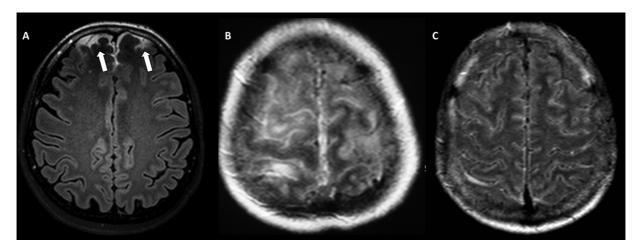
Susceptibility artifact as hyperintense signal within the subarachnoid space. Susceptibility artifact in this case is a hyperintensity focused on the frontal lobes in an axial FLAIR scan (A), mimicking subarachnoid hemorrhage (B) or meningitis (C). Subarachnoid hemorrhage presents as a diffuse hyperintense signal filling the sulci and with blurrier limits. In both cases, the clinical features add a great deal to the differential diagnosis, as well as lumbar puncture findings.
